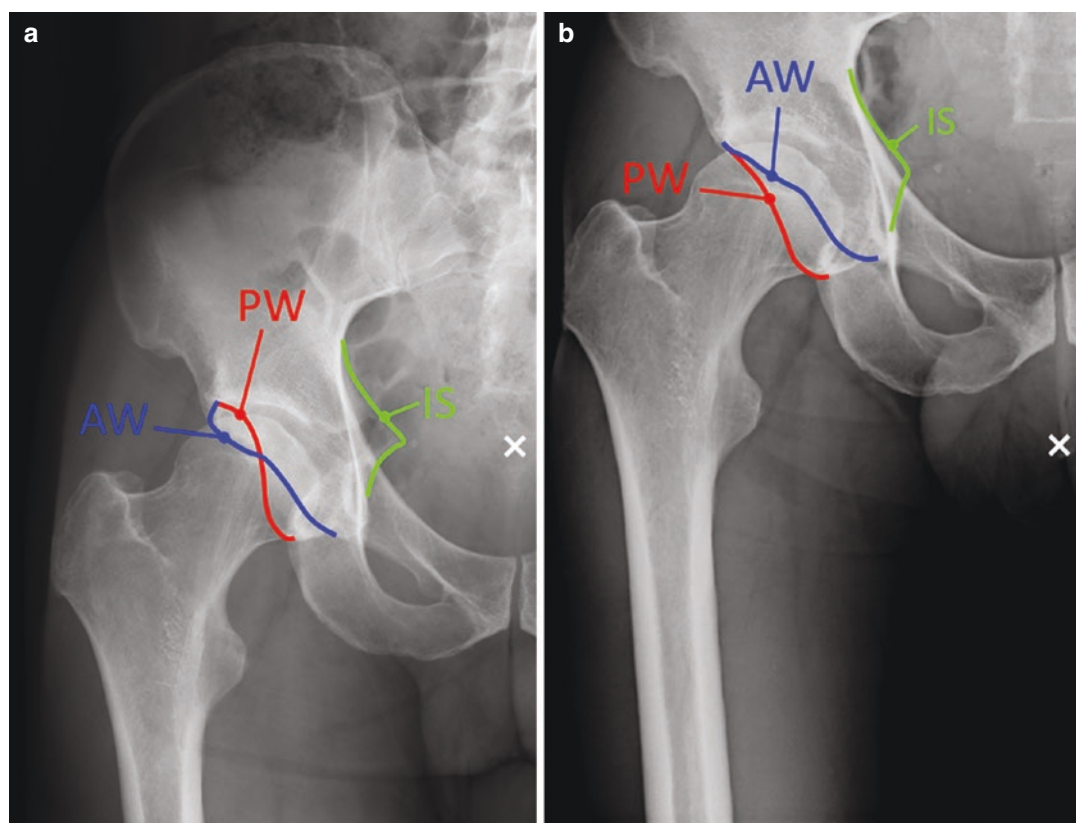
Impact of the level of centration of the central beam (white cross) on the projected hip anatomy. (a) AP pelvic radiograph centered over the pelvis shows a retroverted acetabulum indicated by a more lateral projection of the anterior wall (AW) compared to the posterior wall
